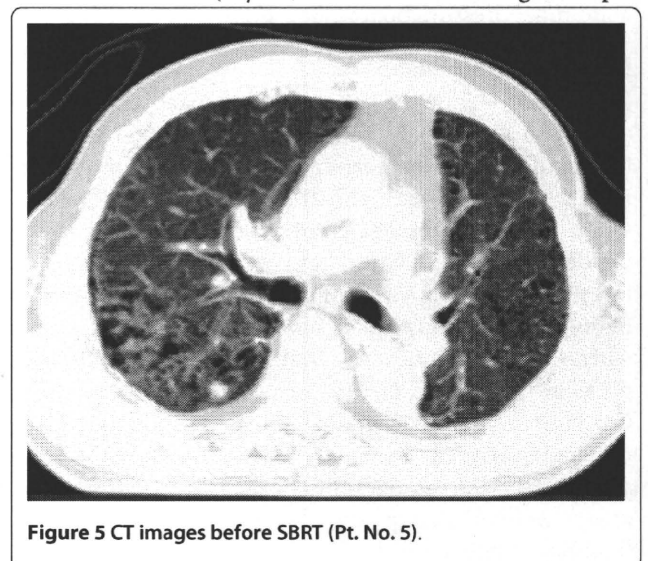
CT images before SBRT (Pt. No. 5).
